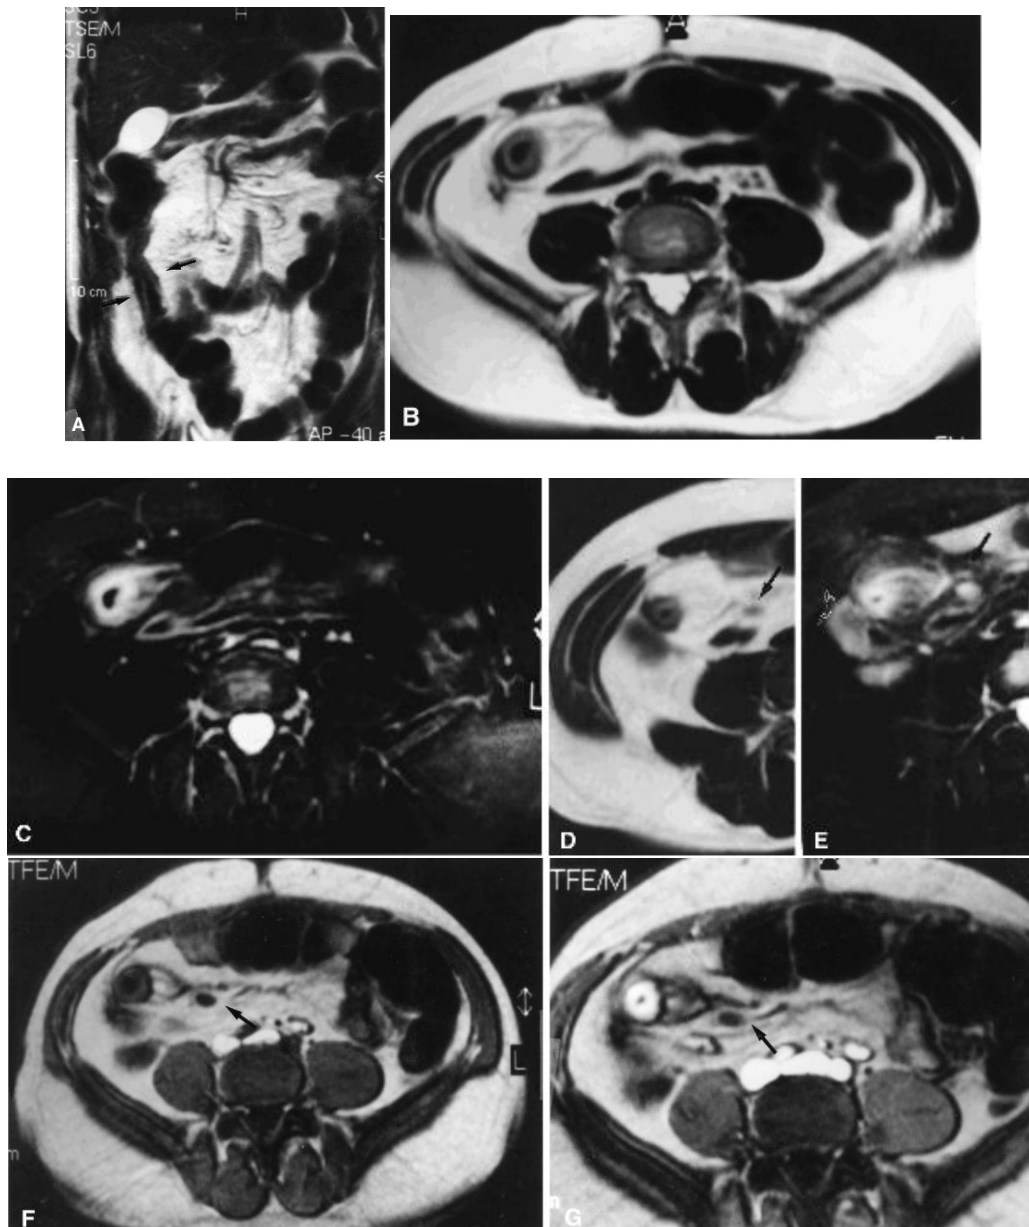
Recurrence of Crohn disease (CD) in a 52-year-old male with previous resection of the terminal ileum and ascending colon. A Coronal T2-weighted TSE image: recurrence of CD at the level of the anastomotic ileal loop is clearly evident (*arrows*). The affected loop has thickened walls and a reduced, irregular lumen more than approximately 10 cm long. B Axial T2-weighted TSE image shows thickening and hyperintensity of the wall of the anastomotic loop, inhomogeneity of the perivisceral fat tissue, and dilation of the afferent vessels. C On the axial fat-suppressed T2-weighted TSE image obtained at the same level, the visibility of wall hyperintensity is greatly improved, as is hyperintensity of the perivisceral fat tissue. Initial signs of wall inflammation are also evident in an adjacent ileal loop. Axial T2-weighted TSE (D) and fat-suppressed T2-weighted TSE (E) images obtained at a higher level. The perivisceral fat hyperintensity is more evident, as is a regional enlarged lymph node (*arrows*), which shows a high signal after fat suppression due to inflammation. F On the breath-hold T1-weighted TFE image acquired at the same level, vascular dilation and prominence of the vasa recta are clearly visible, as is a local enlarged lymph node (*arrow*). G Breath-hold T1 weighted TFE image obtained after intravenous injection of gadolinium shows marked wall thickening and mural enhancement (*arrow*), indicating active mural disease
